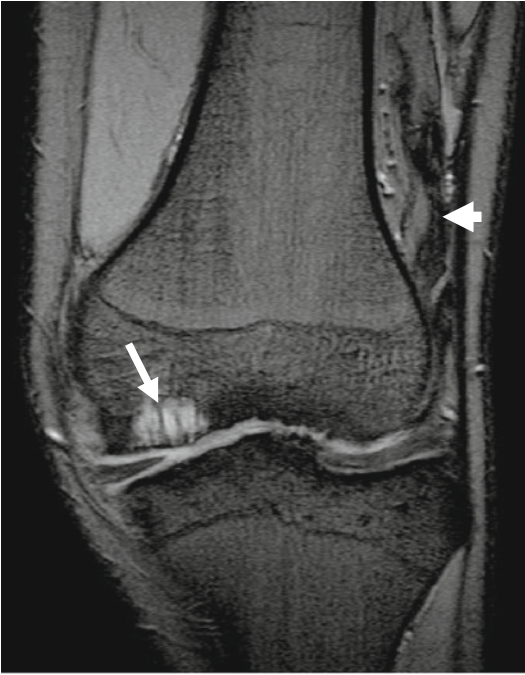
The GRE T2* coronal MRI view of a knee shows subchondral cysts (*arrow*) and mild hemosiderin deposits (*arrowhead*) intensely black, conversely to the adjacent soft tissues
